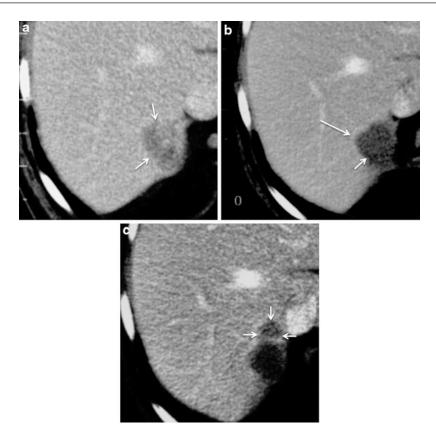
(a) Pretreatment CT from a patient with colon carcinoma and a hypovascular subcapsular right lobe metastasis (*arrows*) adjacent to the IVC. The subcapsular nature of the metastasis and the proximity to the IVC (heat sink) are considerations for ablation. (b) One-month post ablation CT scan demonstrating an ablation defect (*short arrow*) similar in size to the original tumor. This is suggestive of an inadequate ablation margin. Note the faint
